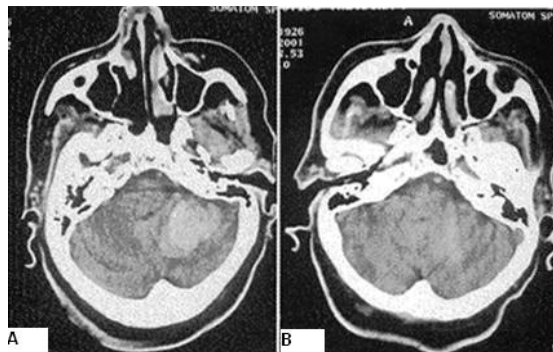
Cerebellar hematoma. A. CT representation on the day of onset. B. Cerebellar hematoma resorption after medical treatment
